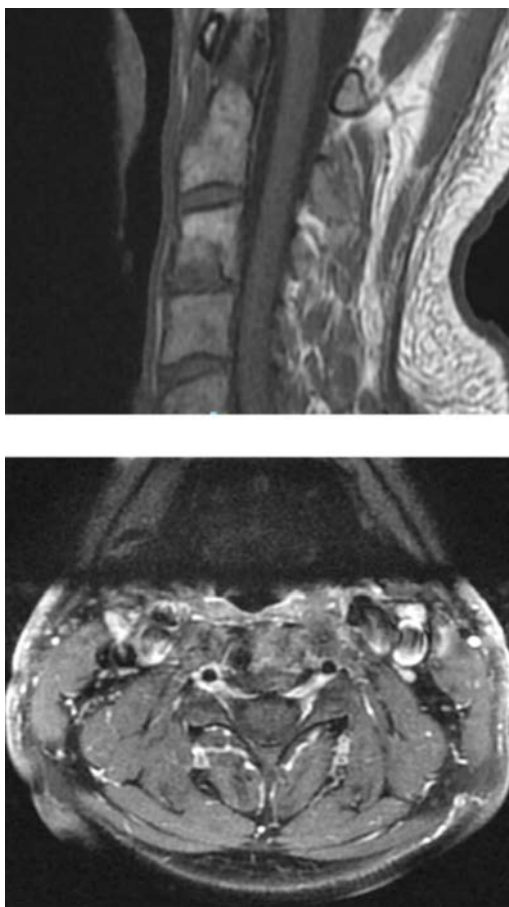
Magnetic Resonance imaging (MRI) of the cervical spine in the sagittal and axial plane revealed bone destruction and erosion in the anterior-inferior part of the body of C3, with enhancement in T1-weight, and STIR sequences before treatment.
